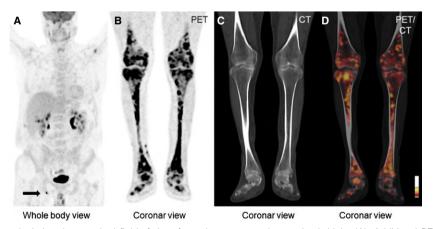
FDG-PET/CT scan depicting the standard field-of-view from the vertex to the proximal thighs (A). Additional PET (B), CT (C), and fused (D) images of the legs. Whereas the standard field-of-view just reveals a single, unspecific FDG-avid lymph node in the right groin (Panel A, arrow), PET of the legs shows intensive symmetric hypermetabolism of both distal femora, tibiae, fibulae, and feet (Panels B–D), highly suspicious for malignancy.
